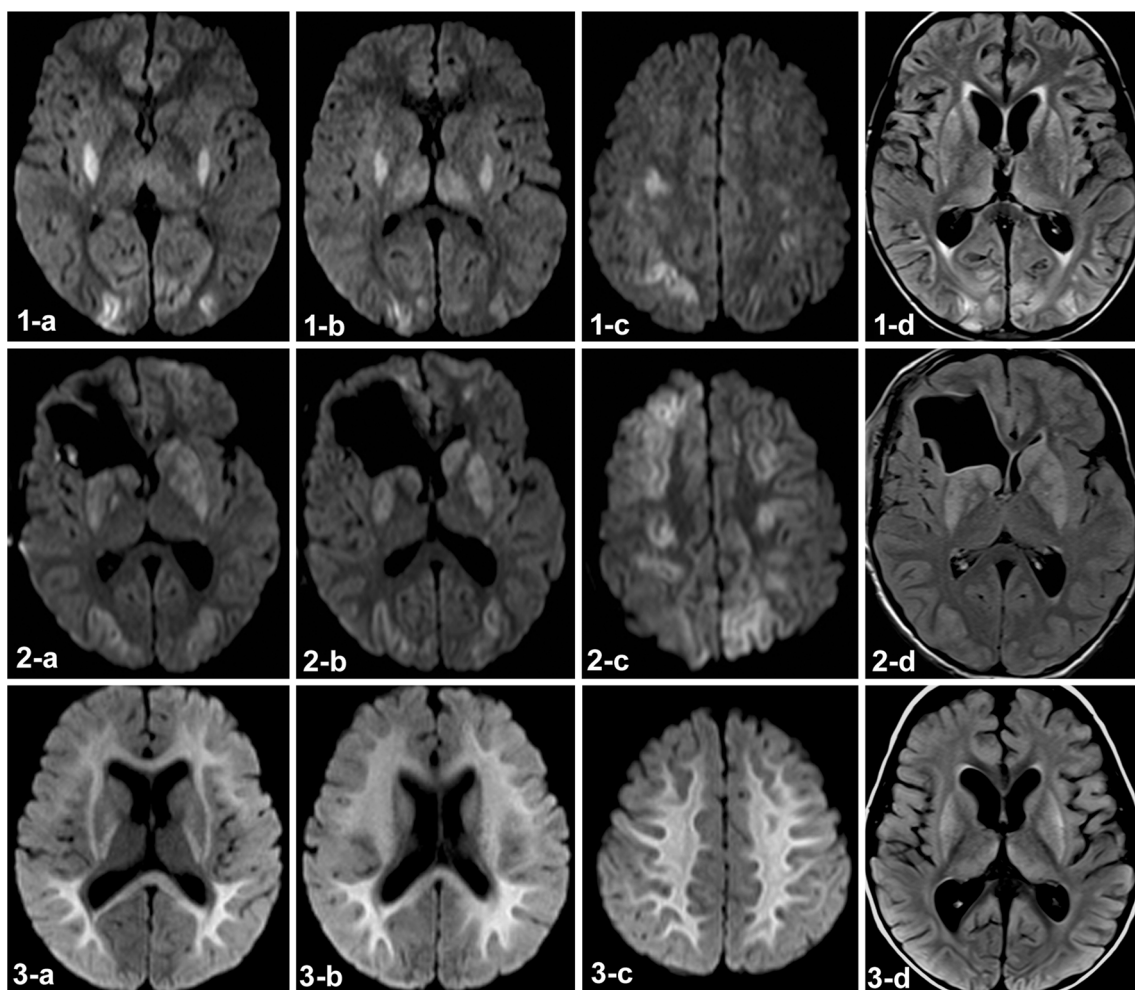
Magnetic resonance imaging of all three patients. The images in the upper panel belong to patient 1. On diffusion-weighted images obtained 2 days post-injury (1-a, 1-b, 1-c), hyperintense signal is seen in bilateral putamen, thalami, and watershed regions of cerebral hemispheres. Corresponding decreased signal is seen on apparent diffusion coefficient map (not shown). Follow up magnetic resonance imaging performed 19 days later revealed atrophy and hyperintense signal in bilateral caudate nuclei and atrophy on fluid-attenuated inversion recovery images (1-d). The images in the middle panel belong to patient 2. On diffusion-weighted images obtained 4 days post injury (2-a, 2-b, 2-c), restricted diffusion is seen in watershed regions of cerebral cortex, bilateral caudate nuclei, putamen, and globi pallidi. A large cavity is located in the right frontal lobe, which is secondary to pre-existing
